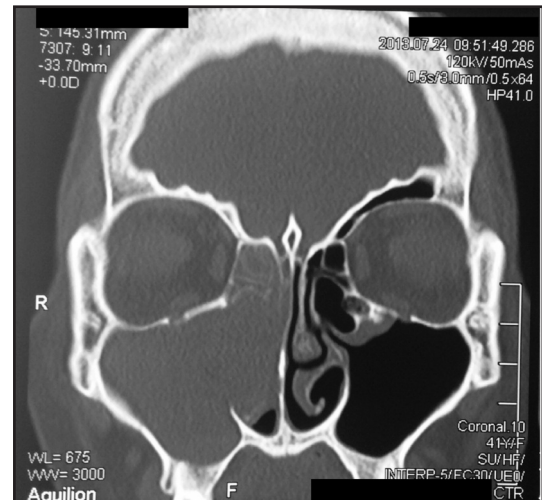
CT scan coronal view homogenous mass at right nasal cavity and right maxillary sinus.
